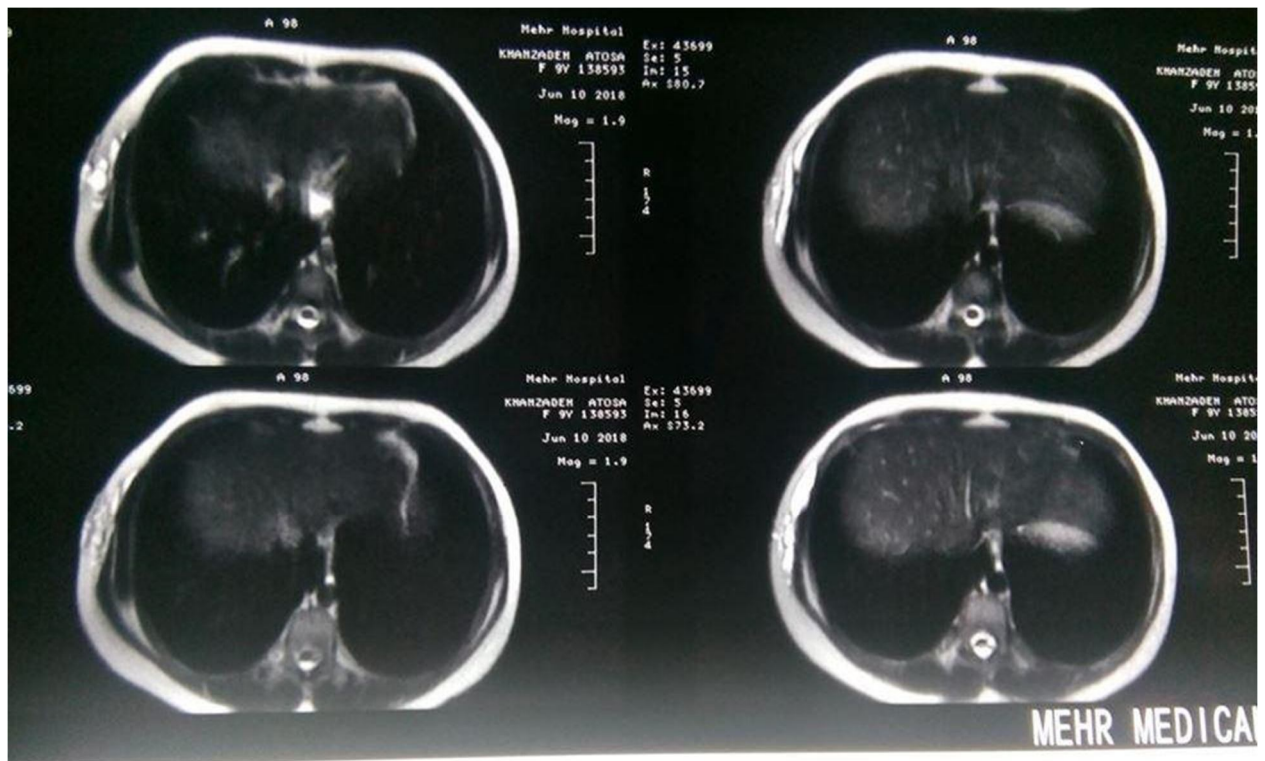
MRI of the chest. T2-weighted, without contrast and without fat suppression.
